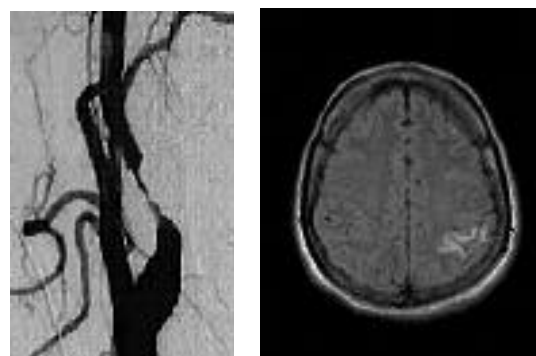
A young patient with transient neurological symptoms. (A) Angiogram shows significant stenosis secondary to internal carotid artery dissection. (B) MRI reveals left parietal infarct.
